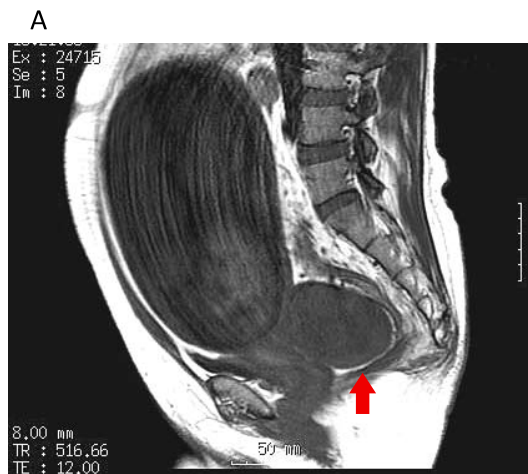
MRI of the pelvis (A: T1 weighted, B: T2 weighted)
